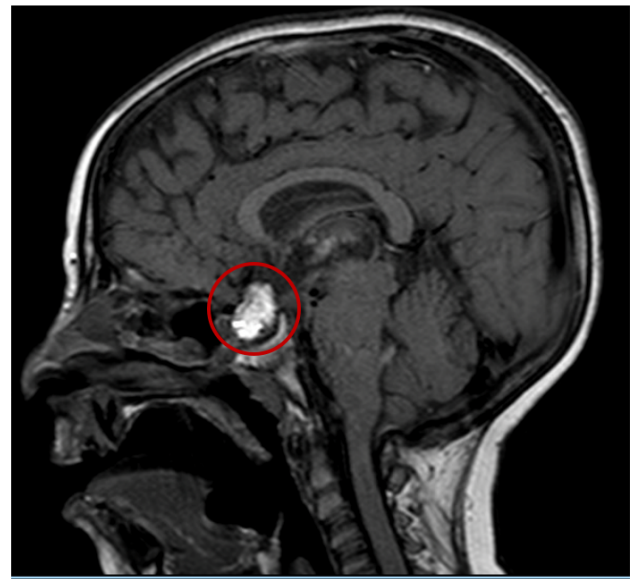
Post-transsphenoidal removal of Craniopharyngioma, sagittal views of MRI brain with contrast demonstrating a 13 x 21 mm organized blood clot at the place of completely resected tumor. Appearing to have high signal intensity on both pre- and post-contrast T1 sequences (right and left panels, respectively).
